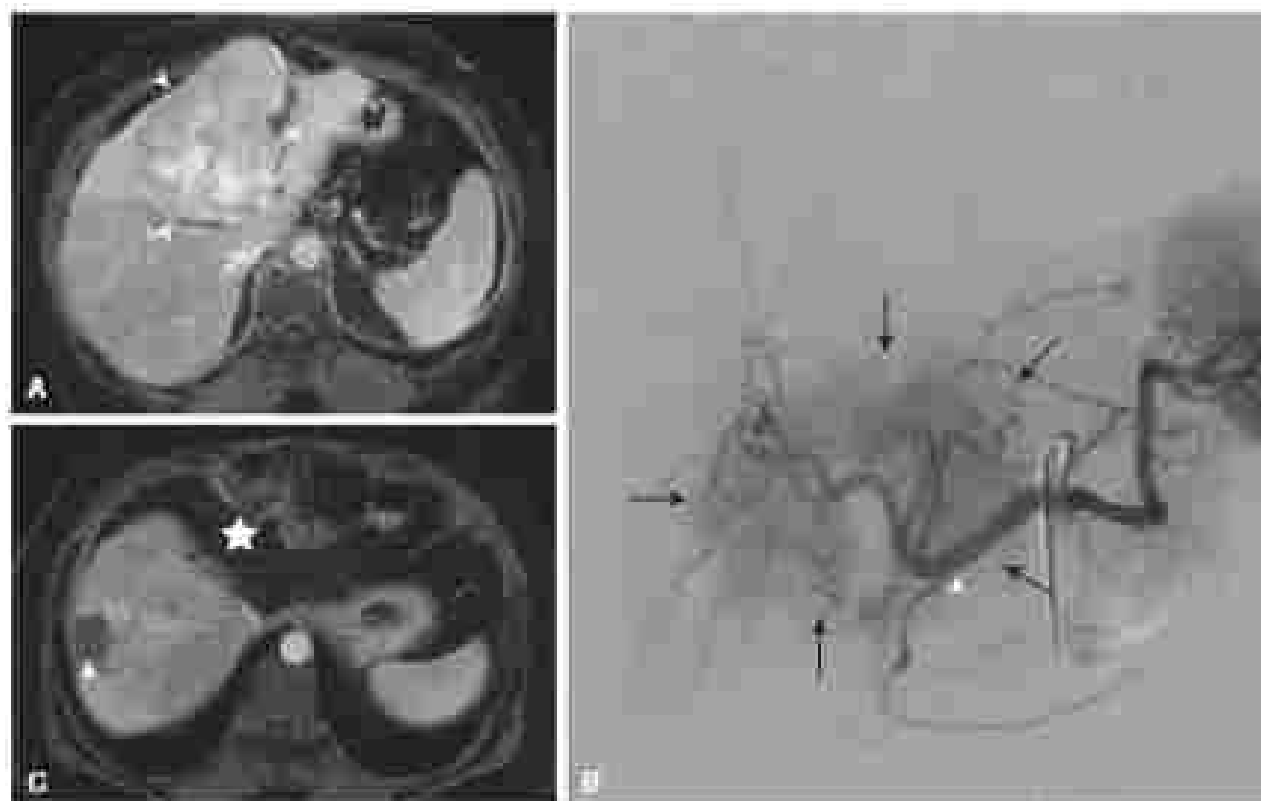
A 31-year-old female with cholangiocarcinoma. (A) Axial contrast-enhanced magnetic resonance imaging shows a large hypervascular mass (arrow) in the right liver lobe. (B) Cholangiogram during transarterial chemoembolization (TACE) shows the hypervascular mass (arrow) being fed by the hepatic artery (arrowhead). After a combination of transcatheter treatment including many TACEs, the patient became recurred. (C) Axial contrast-enhanced magnetic resonance imaging 2 years after initial diagnosis shows the recurrent liver with no radiologic evidence of disease. A completely sclerotic tumor (arrowhead) remains (see other report [14]). Top, Left, Right, and Bottom views are shown.
